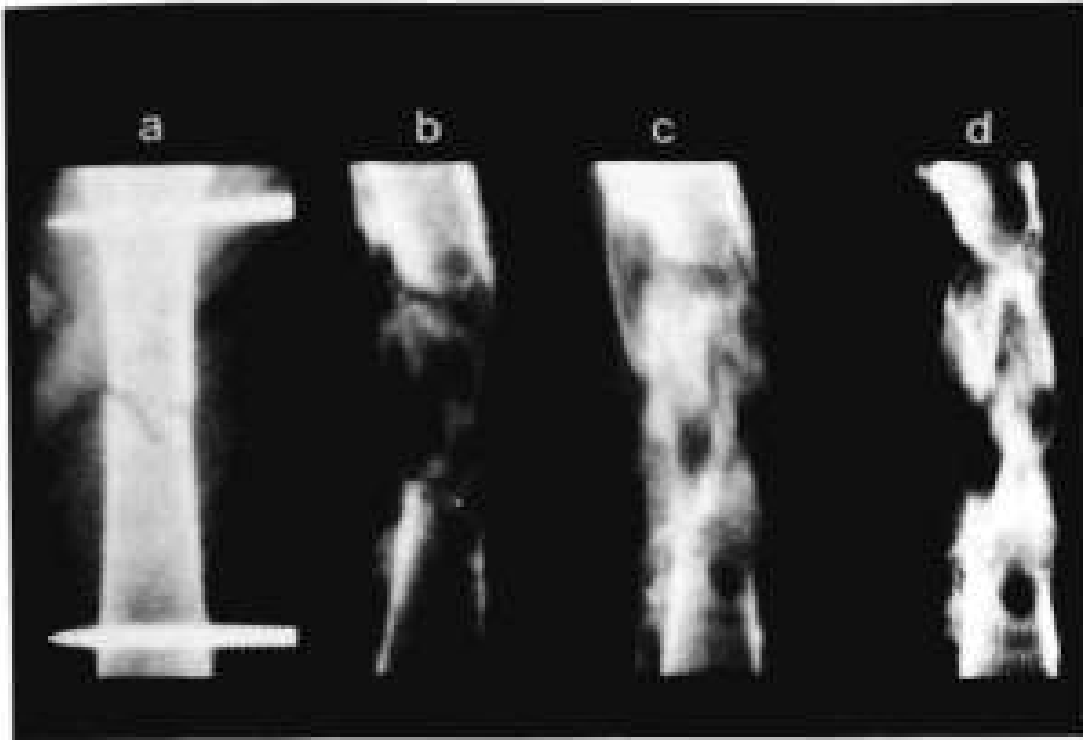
Radiographic image of lengthening callus: (a) immediately postoperatively; (b) 1 month postoperatively; (c) end of distraction period; (d) 3 months postoperatively.
